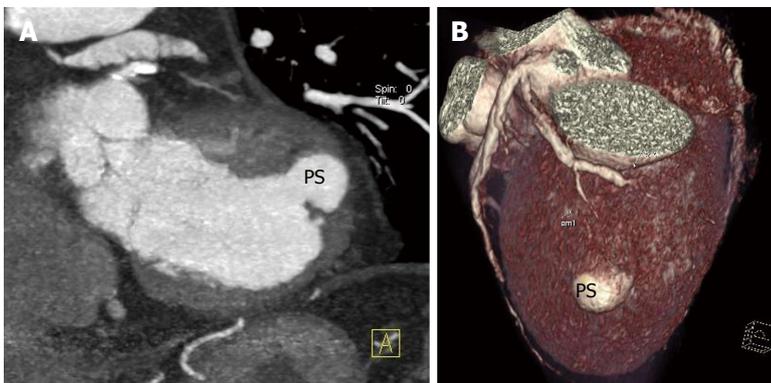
Cardiac computed tomographic angiography and volume rendering: Left ventricle lateral wall pseudoaneurysm (A and B). PS: Pseudoaneurysm.
